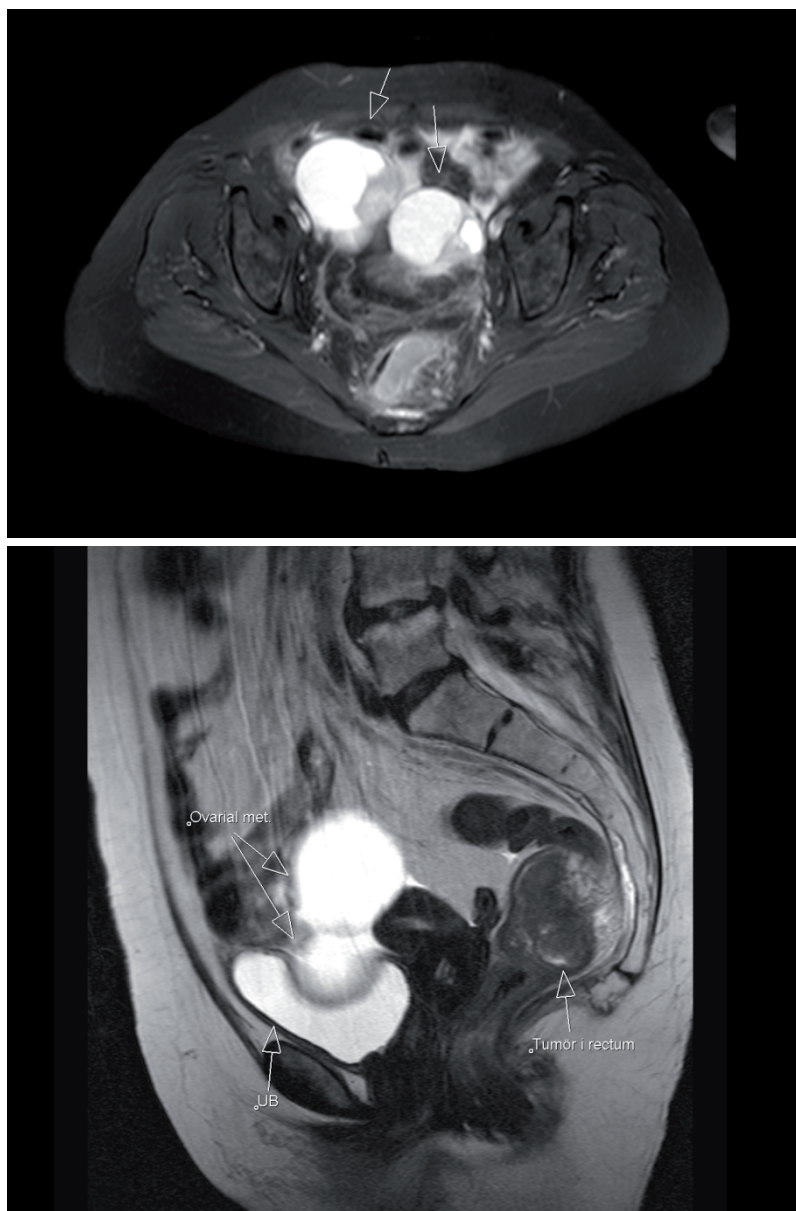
MRI presentation of bilateral ovarian metastases from rectal cancer (arrows).
